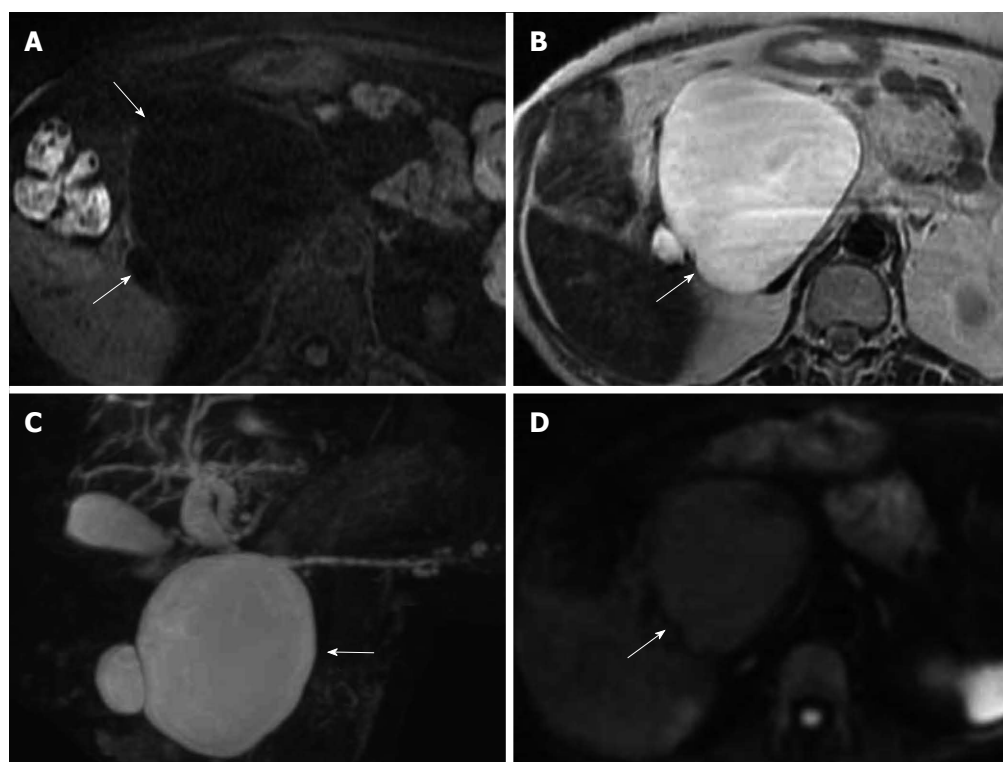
Findings of a case of serous cystic neoplasm. A: Findings of T1-weighted imaging on magnetic resonance imaging (MRI), the cystic lesion showed low intensity (arrow); B: Findings of T2-weighted imaging on MRI, the cystic lesion showed high intensity (arrow); C: Findings of magnetic resonance cholangiopancreatography, the cystic lesion showed high intensity (arrow); D: Findings of diffusion-weighted imaging on MRI, the cystic lesion showed high intensity (arrow).
